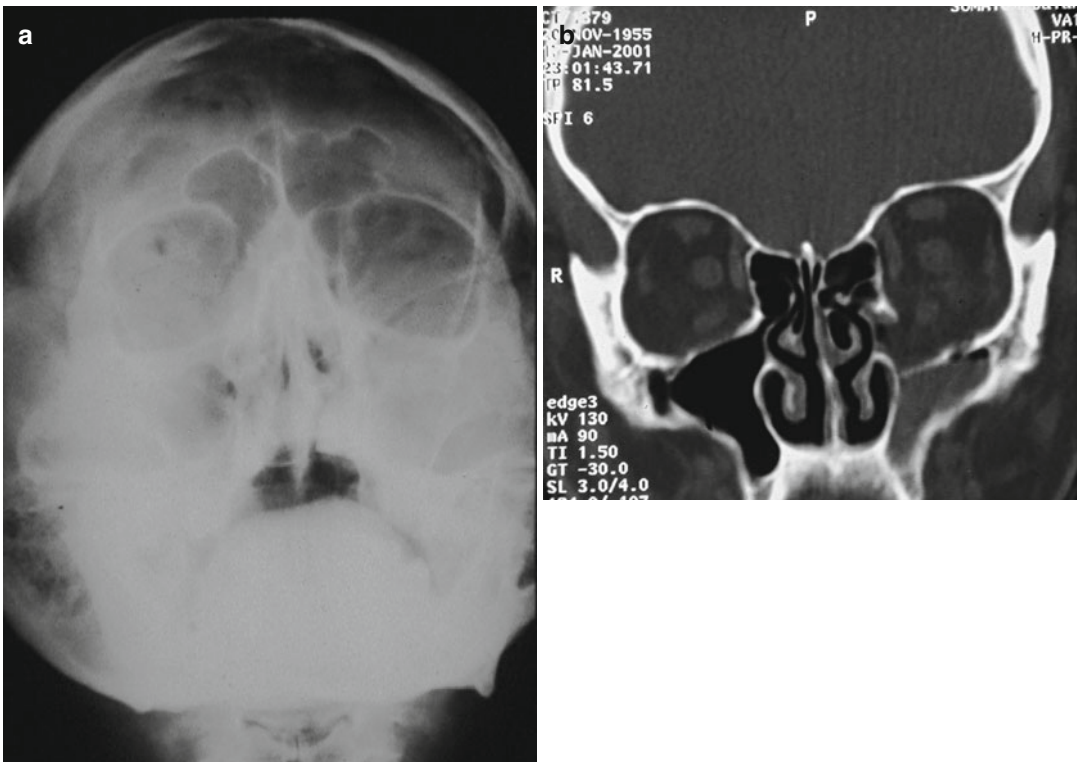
(a) Radiogram—the orbital frame is intact but there are eye symptoms: diplopia and restricted eye movements. (b) The coronal CT image shows a similar lobular bone defect with a lateral ‘shaft’
